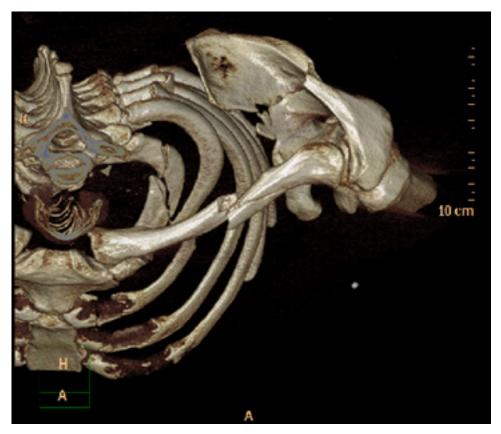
Left thorax and shoulder CT scan. Superior view.
